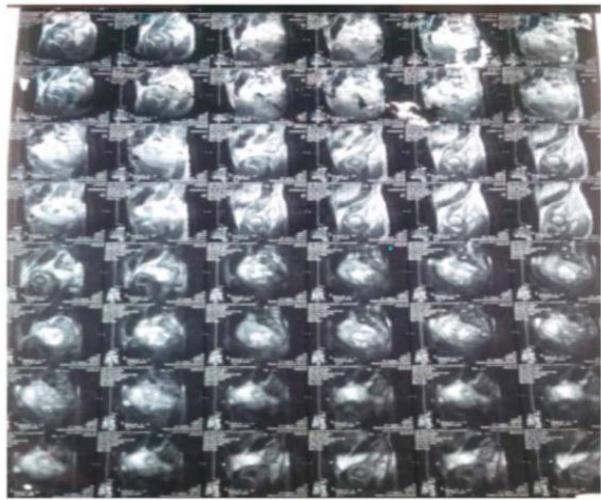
CT of the pelvis shows tissue mass in presacral area
